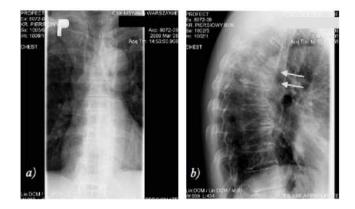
X-ray of the thoracic spine. Projections AP (a) and lateral (b). Compression fractures of Th5 and Th6 shafts [1]
